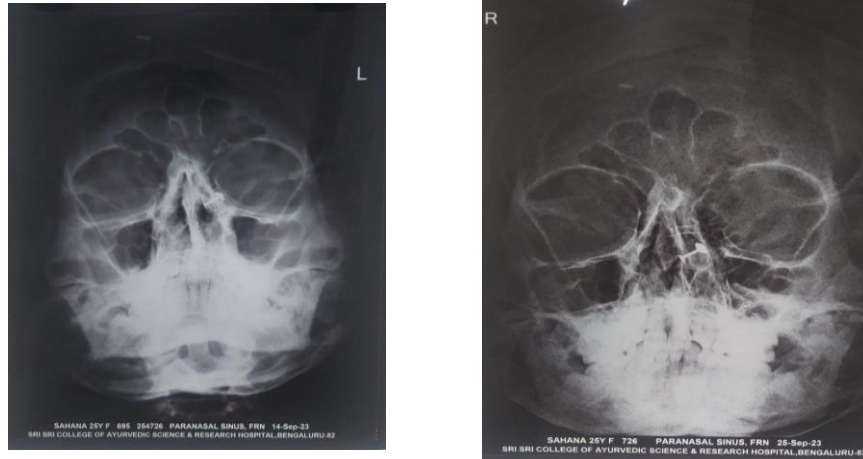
X-Ray PNS (Before treatment) Figure 2: X-Ray PNS (After treatment)
